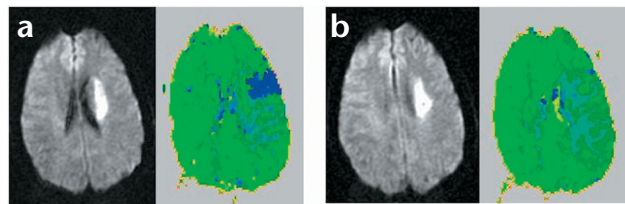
Case 2's DWI (left) and PWI (right) scans before and intervention to restore blood flow. (a) Scans done when written naming of verbs was impaired. (b) Scans after intervention, when written naming of verbs had recovered.
